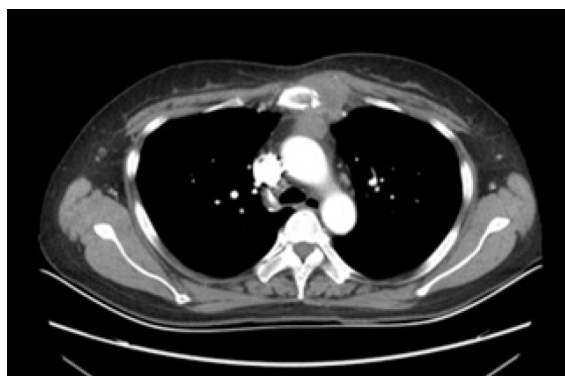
Chest contrast enhanced computed tomography scan. Patchy low-density shadows were seen in the upper sternum, and soft tissue mass formation was observed around the upper sternum, with a size of 3.9 cm × 2.8 cm and slight enhancement.
